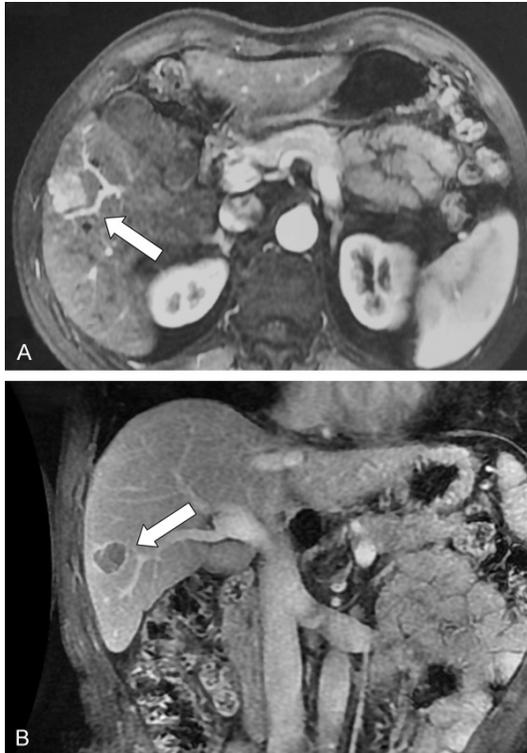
A. Enhanced magnetic resonance imaging (MRI) of the liver revealing an irregular 22 × 20 mm lesion within the segment V, approaching the right anterior branch of hepatic portal vein and the liver capsule. B. Sagittal section of enhanced MRI scan showing the primary lesion in the T1WI delayed phase.
